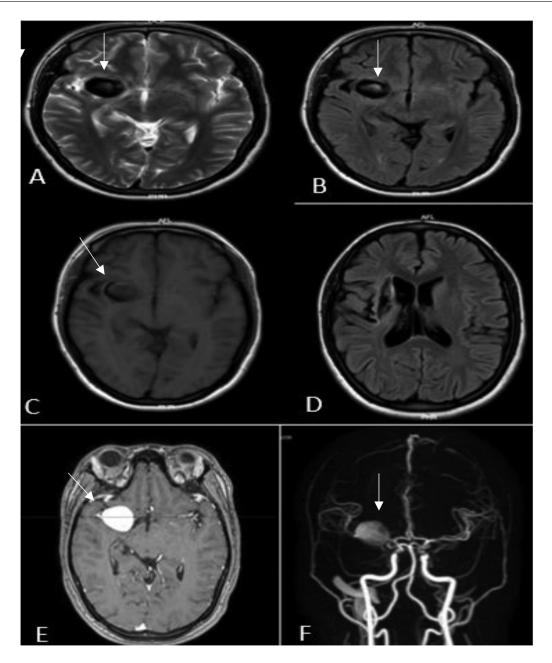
(A-C) Axial T2, FLAIR and T1 slices showing signal void due to aneurysmal formation in the territory of the right middle cerebral artery. (D) Axial FLAIR with encephalomalacia in the territory of the right middle cerebral artery. (E) Axial T1 with contrast showing filling of aneurysmal lesion of the right middle cerebral artery. (F) MIP showing aneurysmal lesion of the M1 segment of the right middle cerebral artery.
